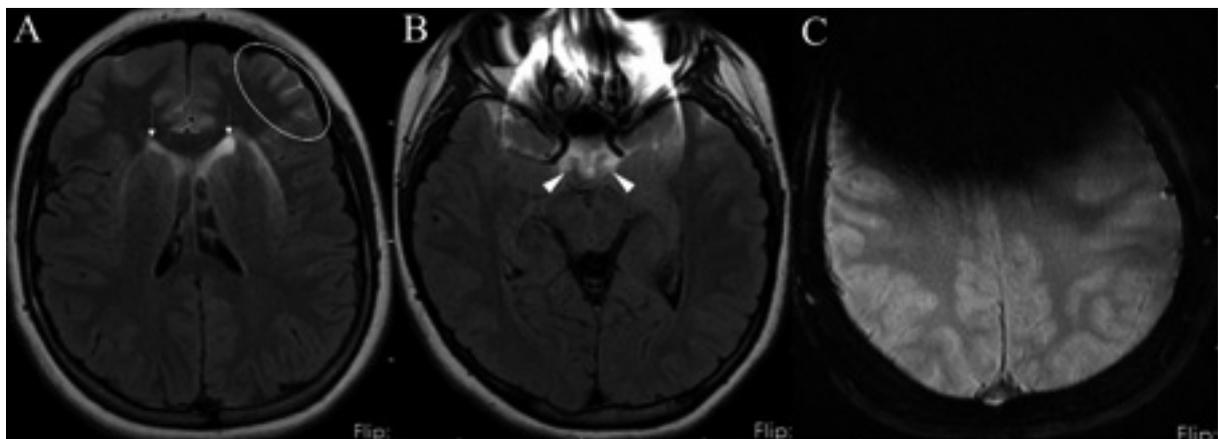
Pseudo-SAH appearance due to braces. A, FLAIR hyperintensities are visible in the left frontal sulci (ellipse) and bilateral lateral ventricular frontal horns (arrows). B, FLAIR hyperintensity at the suprasellar cistern (arrow heads). C, Anterior cranial wide magnetic susceptibility artifact is present on SWI image.
